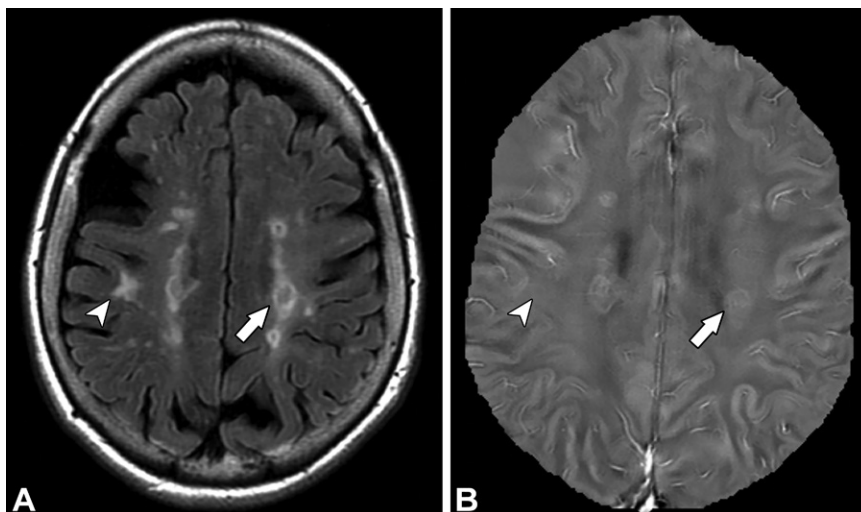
Multiple sclerosis in a 66-year-old man. (A) Axial FLAIR MR image shows multiple hyperintense lesions in the periventricular white matter (arrow) and U-fiber lesions (arrowhead) with no changes on the follow-up images. (B) Axial QSM image demonstrates high contrast (arrow) or isocontrast (arrowhead). High-contrast lesions were estimated to be aged from several weeks to years (early-to-intermediate disease). Lesions with isocontrast were estimated to be 5 years old or older (chronic disease).
